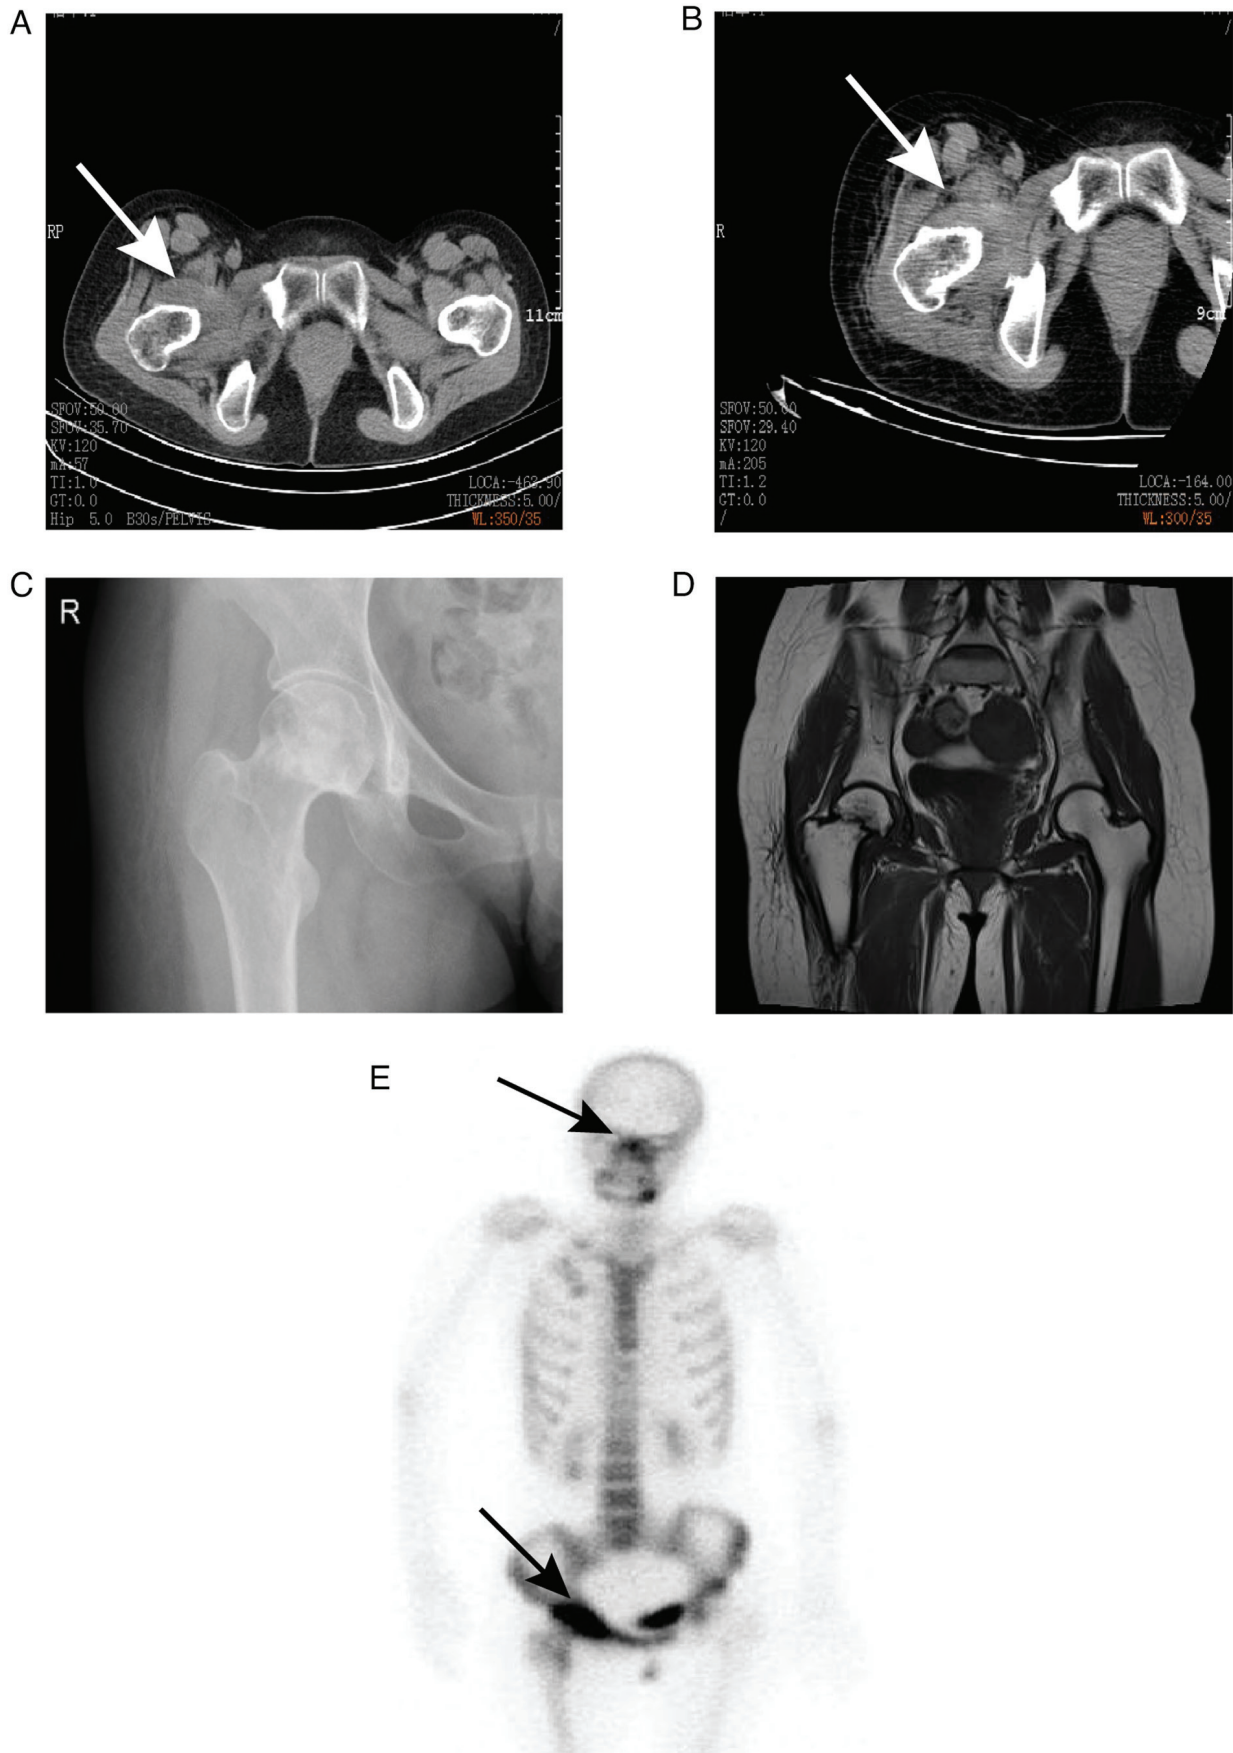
Radiological imaging. (A) Mass around the right hip joint observed in CT imaging (white arrow; July 2022). (B) A similar mass (white arrow) around the right hip joint in subsequent CT imaging (July 2023). (C) Increased density shadow (white arrow) observed in the right acetabulum and right femoral head and neck on X-ray imaging (May 2023). (D) Right femoral neck fracture (white arrow) identified in magnetic resonance imaging (August 2023). (E) Single-photon emission CT/CT imaging revealed heightened metabolic activity in the right acetabulum, ischium and upper thighbone, with increased radioactive uptake in the nasopharynx (black arrows; March 2022).
